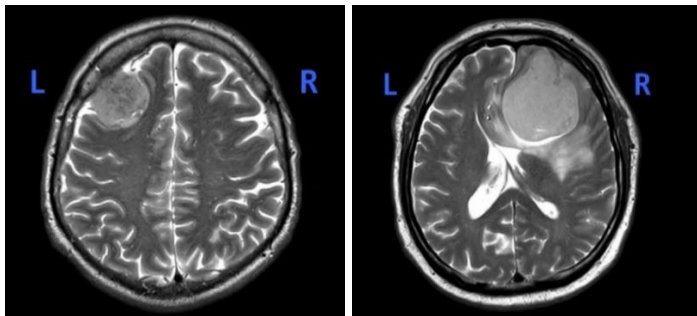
T2-weighted MR image of F-LH (left side) and F-RH (right side)
